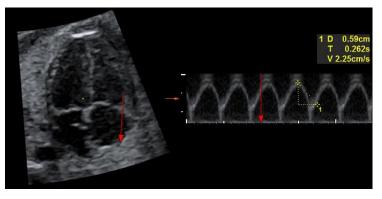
2D slice of 4D STIC ultrasound volume of fetal heart in 4-chamber view and TAPSE measurement using M-mode (red-arrow) and calculated displacement
